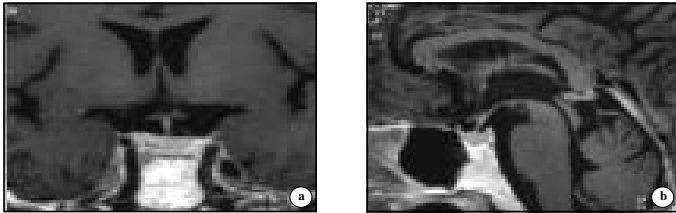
Gadolinium-enhanced a) coronal and b) sagittal sections of MRI of the sella turcica showing normally looking pituitary gland without evidence of pituitary adenoma.
